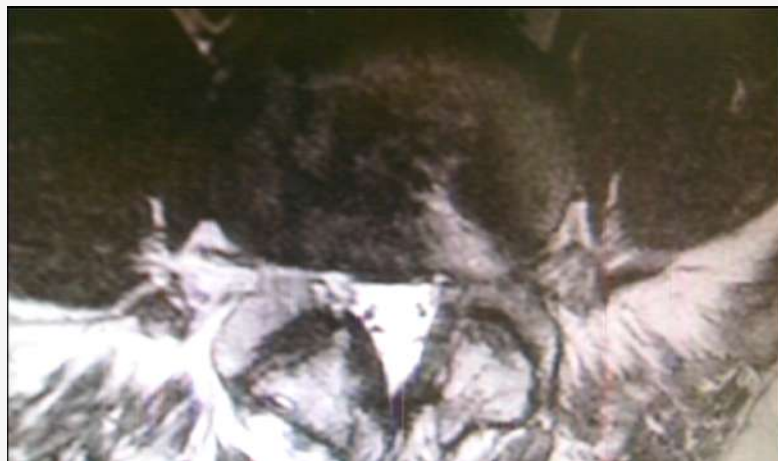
MRI of FBSS following two open decompressions from midline and Wiltse approach. Patient had residual symptoms of numbness from persistent lateral stenosis.
